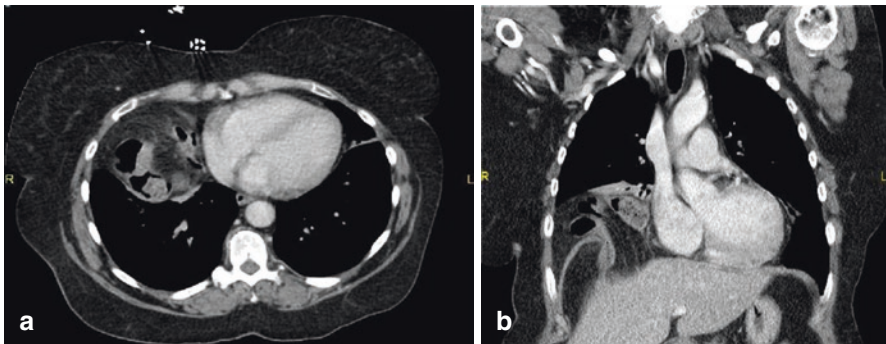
(a, b) Representative (a) axial and (b) coronal CT scan images from the case of a 61-year-old female from our institution who presented with a traumatic right-sided diaphragmatic hernia 2 weeks after motor vehicle collision. Herniated contents included the omentum and colon. She underwent thoracoscopic hernia repair using interrupted #0 Surgidac sutures (Covidien, Dublin, Republic of Ireland)
